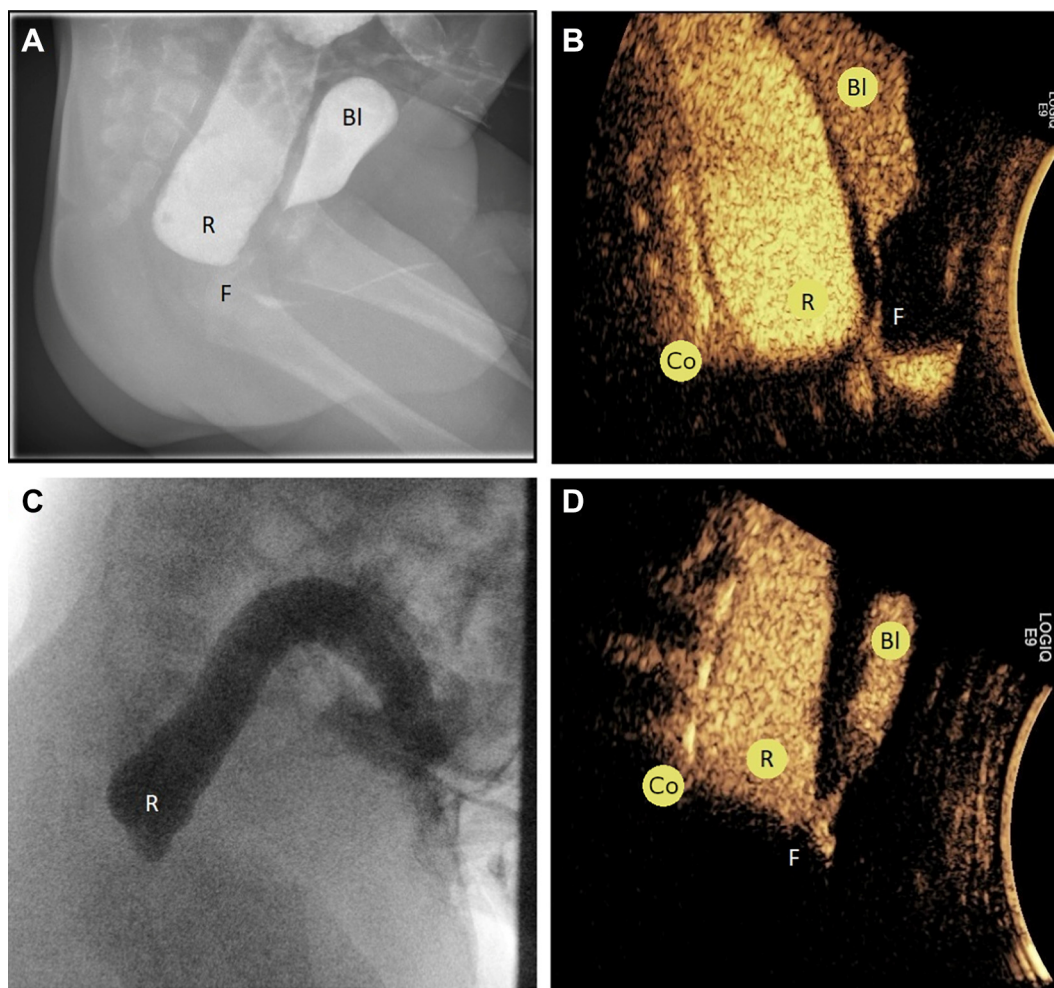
Comparison of traditional colostogram (A, C) with contrast enhanced ultrasound (B, D). Abbreviations: rectum (R), bladder (BI), fistula (F), coccyx (Co). Images A and B are obtained from the same patient, and both methods successfully identify the rectourethral fistula. Images C and D are from a different patient, in which the contrast enhanced ultrasound identified a fistula that was not demonstrated on colostogram.
